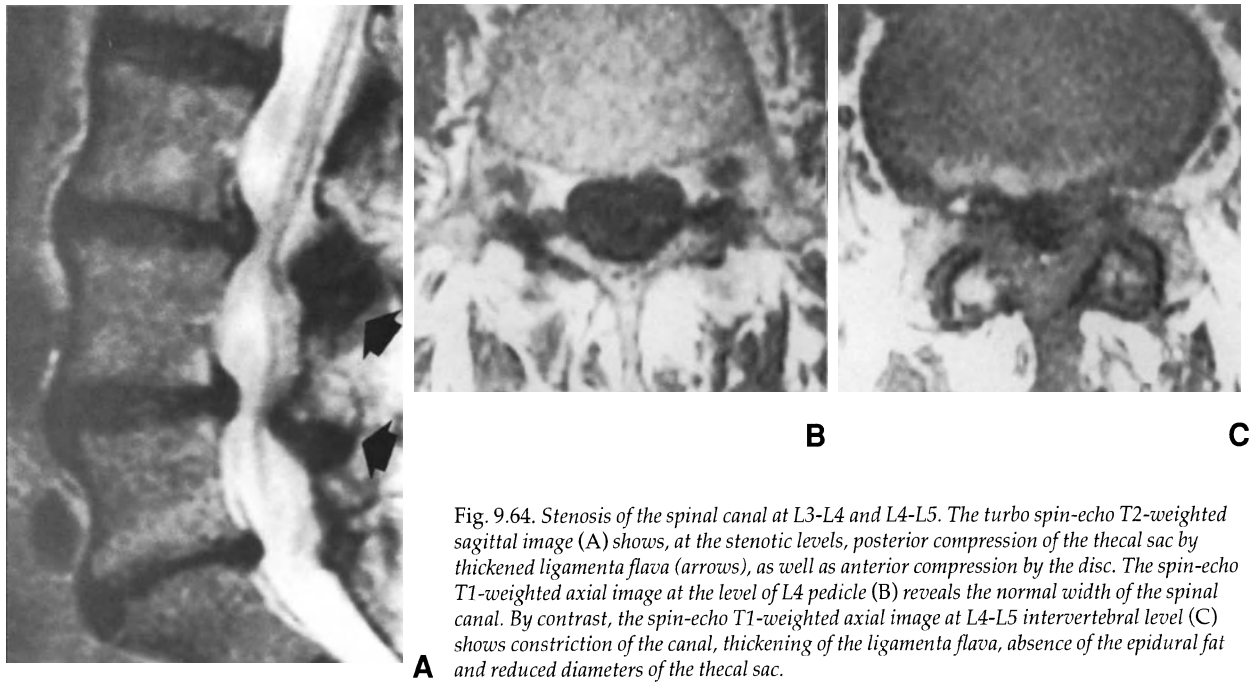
Stenosis of the spinal canal at L3-L4 and L4-L5. The turbo spin-echo T2-weighted sagittal image (A) shows, at the stenotic levels, posterior compression of the thecal sac by thickened ligamenta flava (arrows), as well as anterior compression by the disc. The spin-echo T1-weighted axial image at the level of L4 pedicle (B) reveals the normal width of the spinal canal. By contrast, the spin-echo T1-weighted axial image at L4-L5 intervertebral level (C) shows constriction of the canal, thickening of the ligamenta flava, absence of the epidural fat and reduced diameters of the thecal sac.
